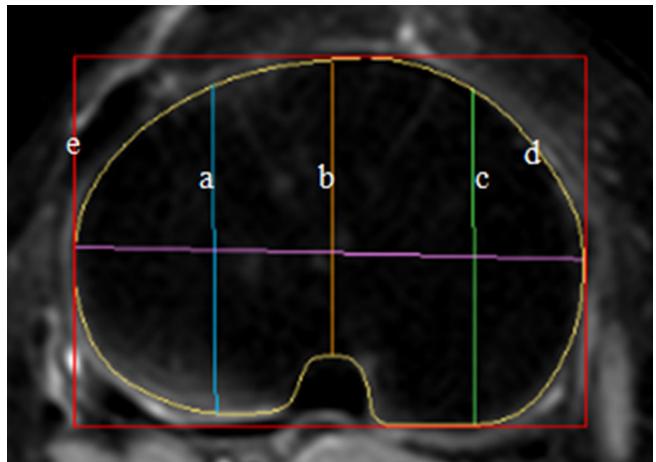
Axial MRI image of the proximal tibia showing (a) the lateral anteroposterior length (LAP), (b) the anteroposterior length (AP), (c) the medial anteroposterior length (MAP), (d) the plateau area, and (e) the bounding box area.
